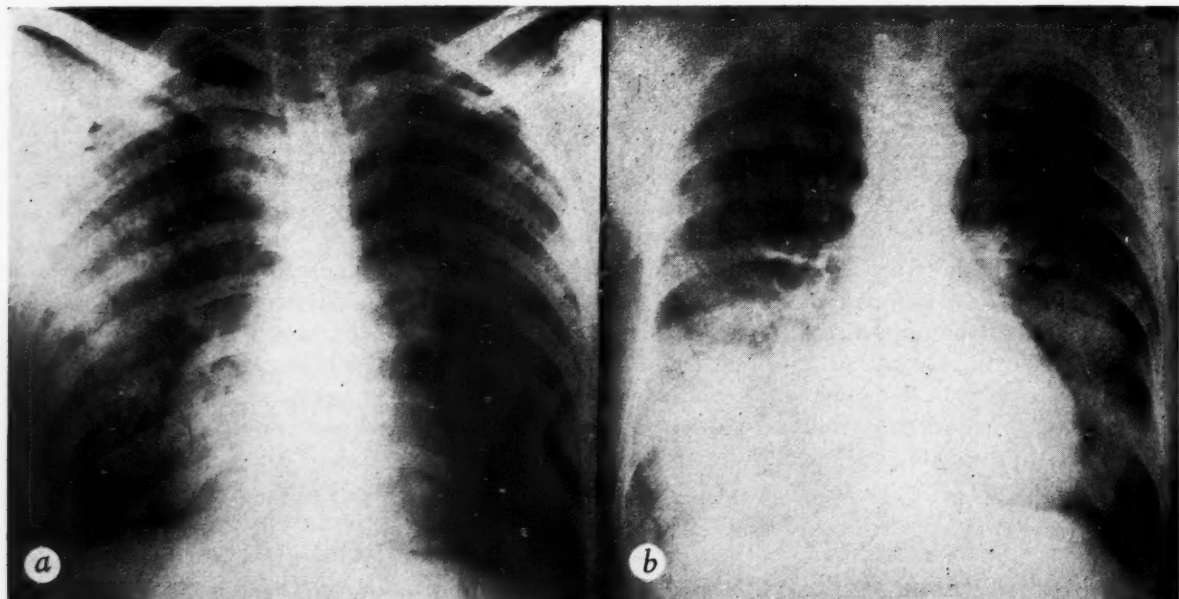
a*, (Case v). Roentgenograms of thorax taken one day before death. *b*, For comparison, a roentgenogram of the thorax of a fifty-seven year old woman who had nephritis and recurrent hemoptysis. Roentgenogram taken during a non-fatal attack of respiratory distress. At this time the blood urea level was 126 mg. per 100 cc. of blood. It is suggested that the roentgenographic picture represented hemorrhage resulting from an attack of acute necrotizing alveolitis which later healed. (See Comment for further details of case.)
